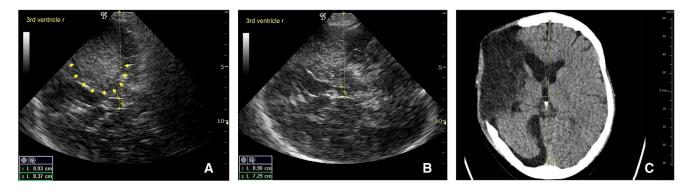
A 32-year-old female patient with craniectomy following space-occupying media infarction on the right side. (A-C) Course of midline shift (MLS) from the left to the right hemisphere. (A) Transcranial B-mode sonography (TCS) on day 4 after admission to the weaning and early neurorehabilitation unit: MLS of 1.6 mm to the left and marked right-sided hemorrhagic transformation. (B) TCS follow-up on day 14 after admission: decrease of the infarct with a mild nonsignificant MLS of 4.1 mm now to the right. (C) CT on day 25 after admission confirms a further decreasing MLS to the right.
